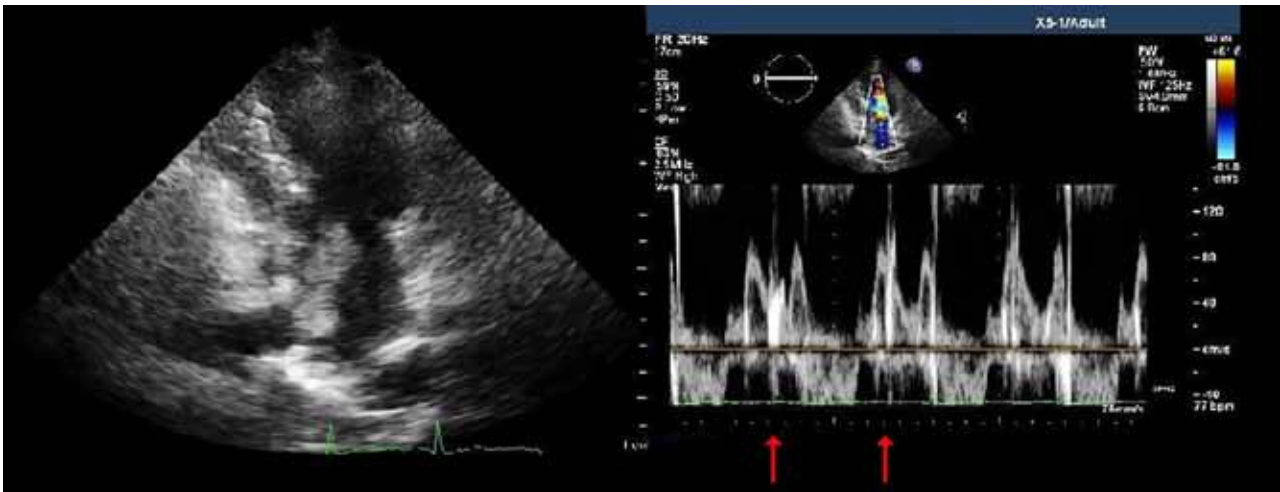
A. Transthoracic view of the mass protruding through the mitral valve. B. Transmitral flow. Red arrows indicate the signs that correspond to tumor plop.
